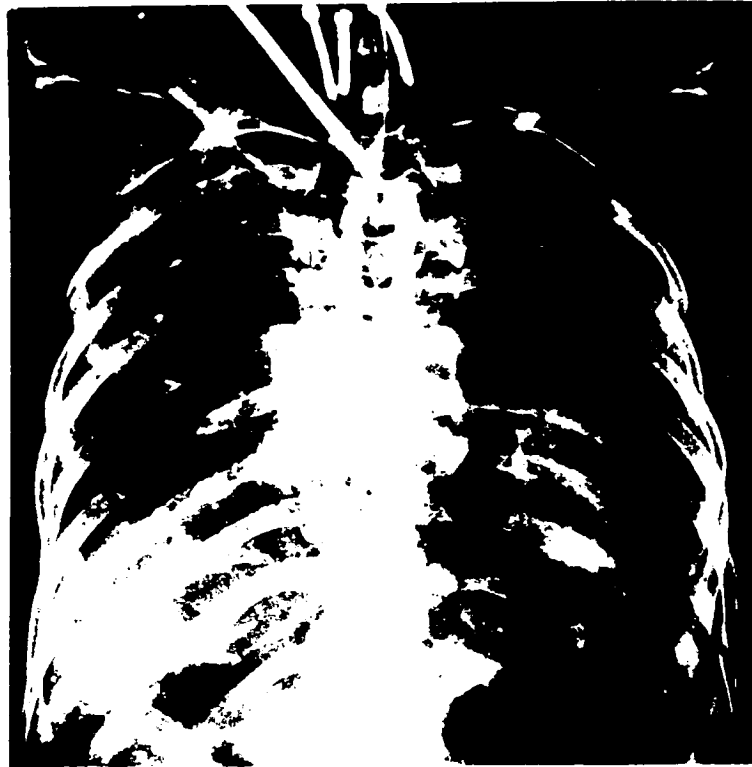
Anterior-posterior thoracic radiograph.
